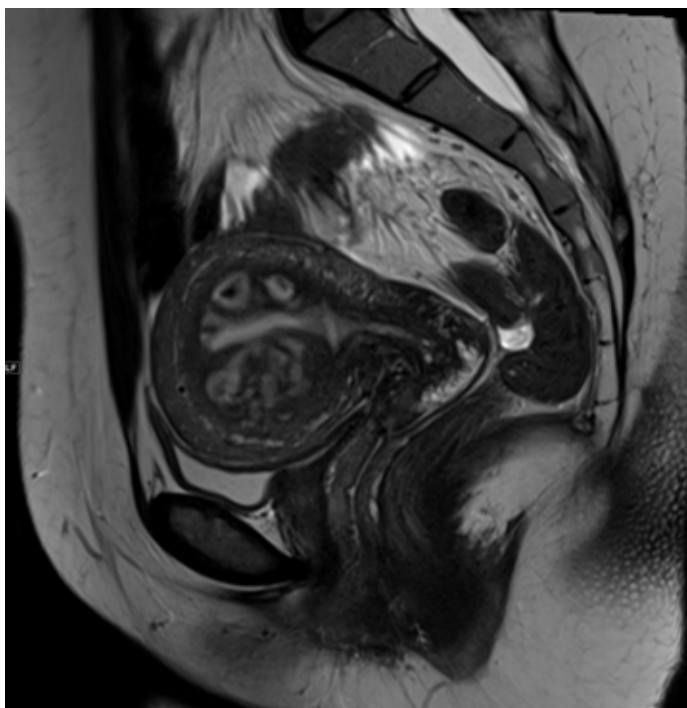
A 47-year-old woman with a suggested diagnosis of uterine sarcoma on CT scan. A sagittal T2 weighted image shows uniform cystic change which conforms to the junctional zone of the uterus owing to adenomyosis.
